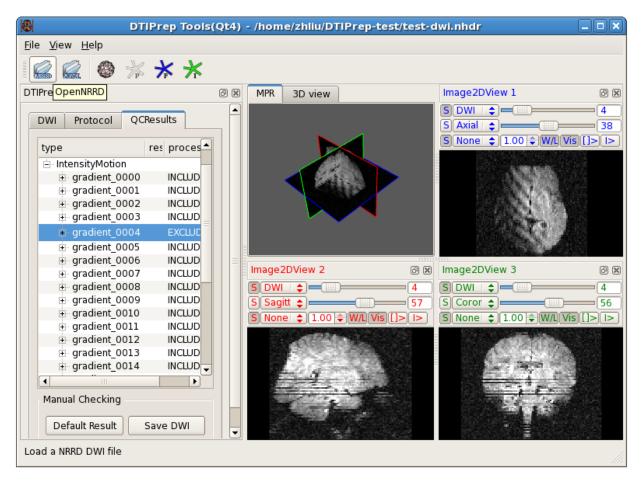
DTIPrep is running in GUI mode. In this picture, the #4 gradient shows intensity artifacts in several slices and it is marked as *EXCLUDE* in the QC result table, indicating that it will be excluded when the *Save DWI* button is clicked.
